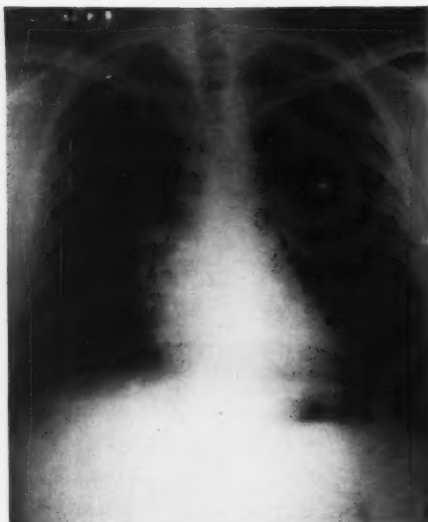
Roentgenogram of the chest two months after admission, showing persistence of a pericardial fluid level.
